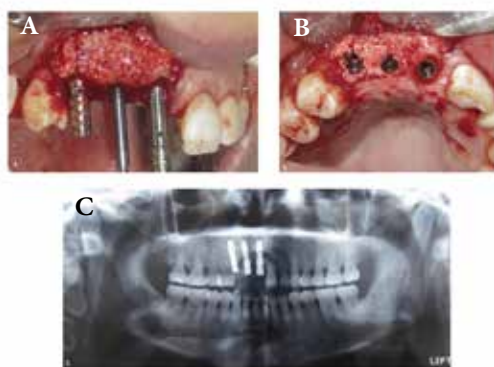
Implant inserted through surgical guide A) Frontal view B) Occlusal view C) Radiographic view.
